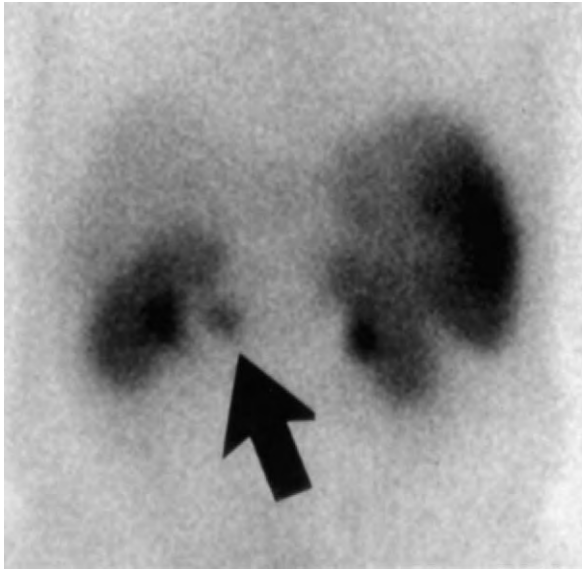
Somatostatin receptor scintigraphy showing a lesion that is consistent with a gastrinoma (arrow) within the area of the gastrinoma triangle. On exploration, the lesion was found in the medial wall of the duodenum.
